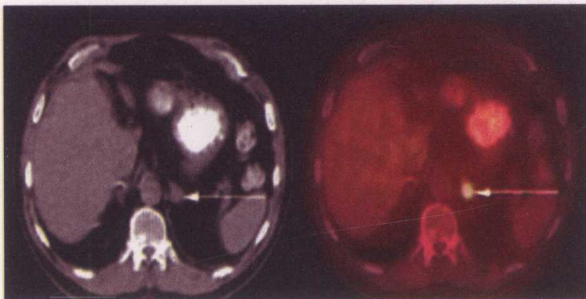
CT (left) with Fusion PET image (right) on same patient.
